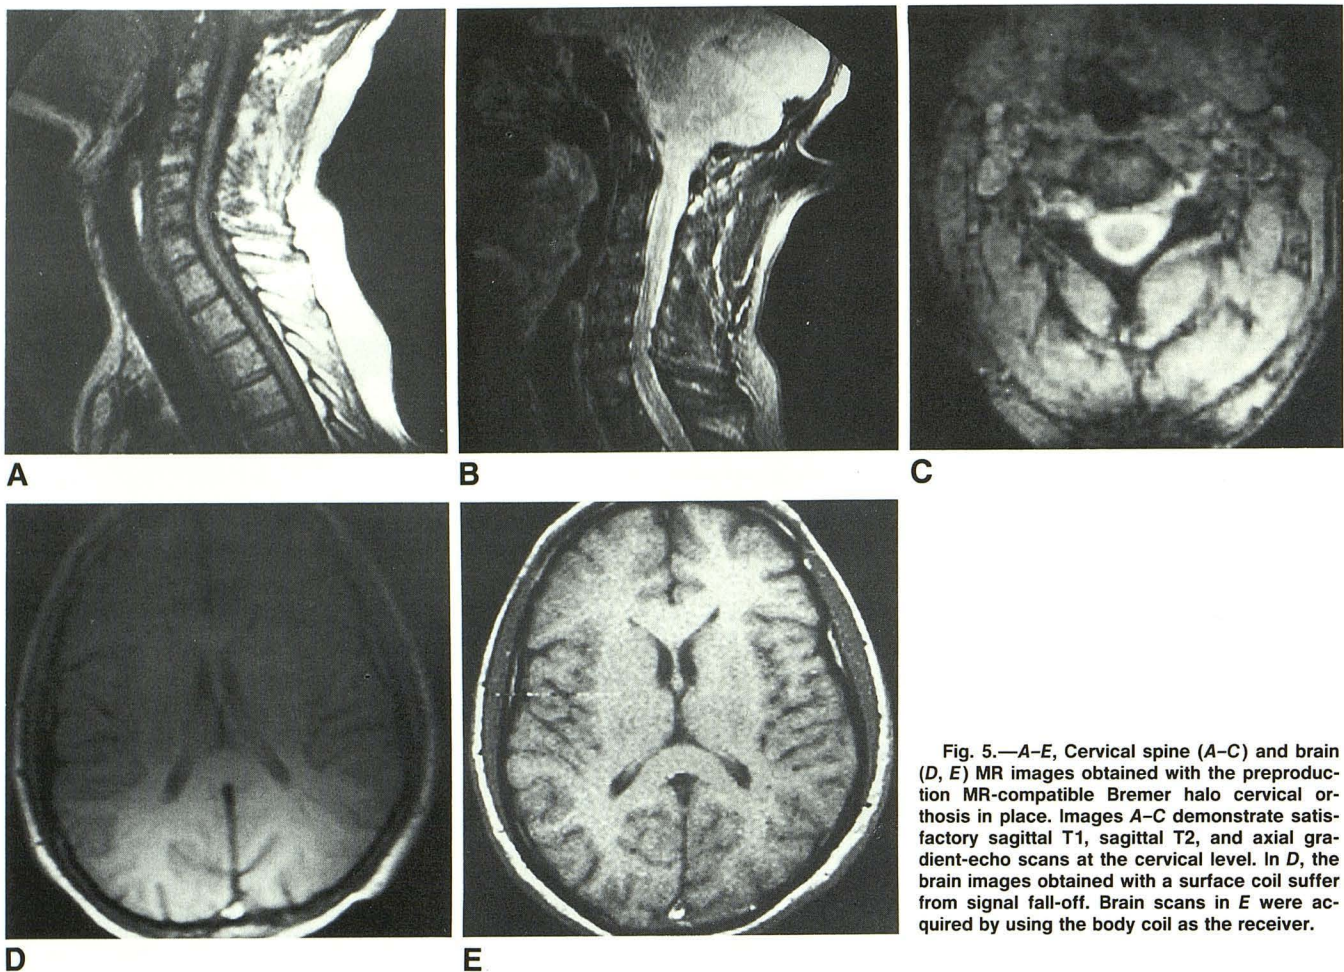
A–E, Cervical spine (A–C) and brain (D, E) MR images obtained with the preproduction MR-compatible Bremer halo cervical orthosis in place. Images A–C demonstrate satisfactory sagittal T1, sagittal T2, and axial gradient-echo scans at the cervical level. In D, the brain images obtained with a surface coil suffer from signal fall-off. Brain scans in E were acquired by using the body coil as the receiver.
